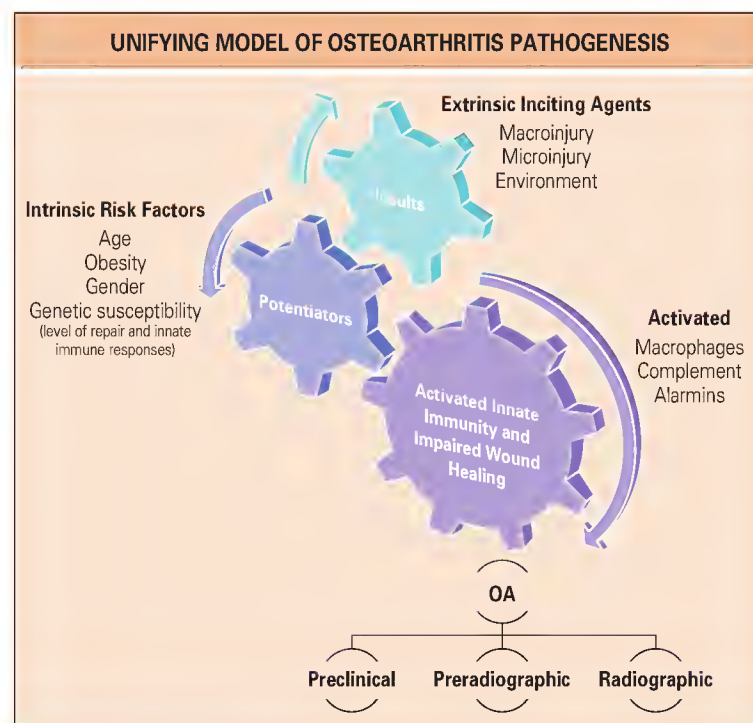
This model depicts osteoarthritis (OA) as a condition incited by the mechanical insults of microinjury, macroinjury, and environmental factors. The interaction of extrinsic inciting insults with potentiating intrinsic factors determines the relative susceptibility to progression of disease mediated by a biologic innate immune inflammatory response analogous to a chronic wound. The resulting pathology is manifested first as a preclinical (not clinically recognizable) entity, with progression in some individuals to preradiographic stages (detected by sensitive imaging modalities) and eventually to radiographic stages. The interacting cogwheels, able to turn intermittently, depict the penchant for OA activity to wax and wane. The exact timing of the onset of the illness of OA that includes symptoms in this continuum of OA pathogenesis is unclear at present.
